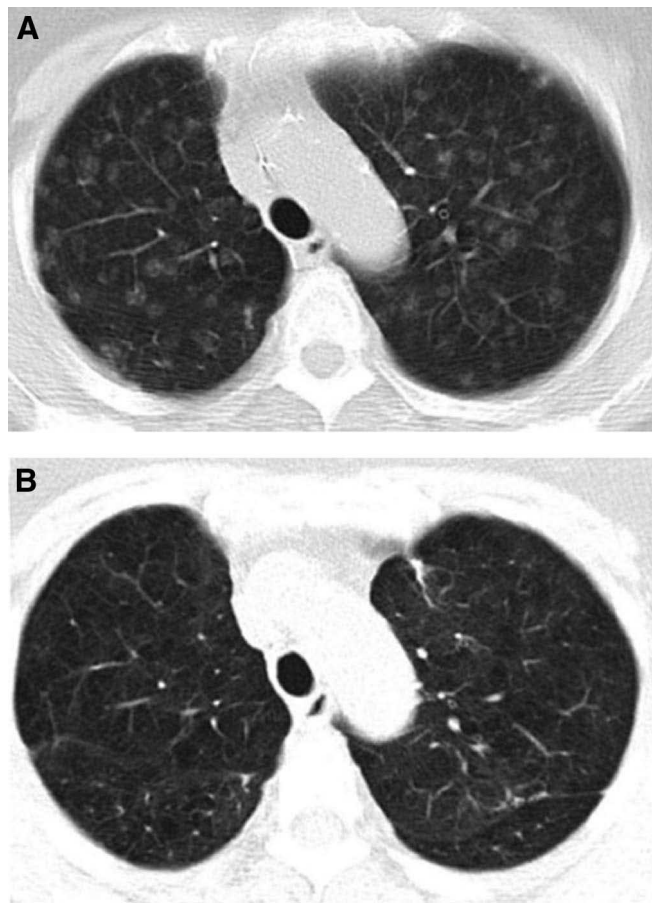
A, Chest computed tomography as on November 2004 showing disseminated bilateral ground-glass opacity, ranging from 5 to 20 mm. B, Chest computed tomography after 12 months of Gefitinib therapy showing complete resolution of ground-glass opacity.
